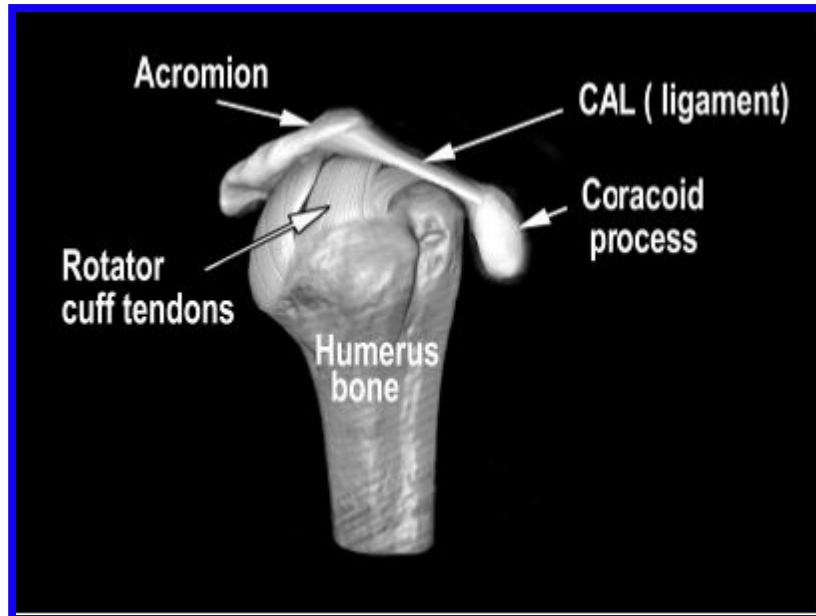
An artist's rendering of the CA arch. The CA arch (solid white arrows) is highlighted. The outlined arrow indicates the tendons of the rotator cuff. The upper arm bone, the humerus, is labeled. For clarity, the bursa beneath the CA arch is left out (the sub-acromial bursa). The view is of a right shoulder from the side. The image was created from a combination of the artist's work overlaid on CT imagery of the skeletal parts.
